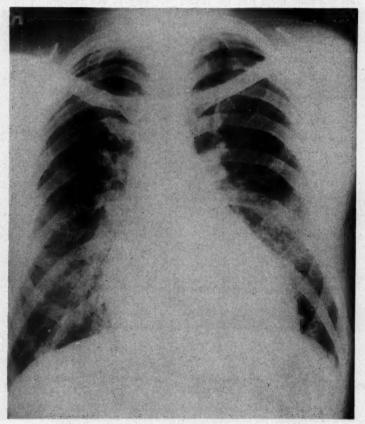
X-ray of heart on December 2, 1954, showing gross enlargement and pulmonary congestion.
